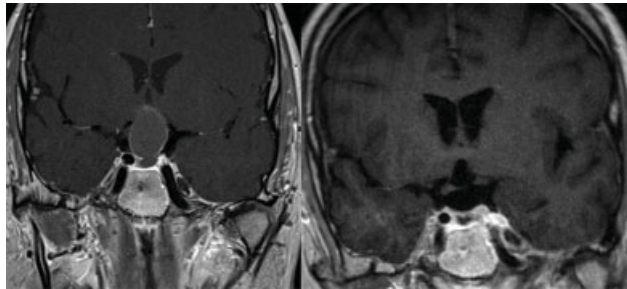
Preop and postop coronal MRI imaging of a craniopharyngioma resected using the endoscopic endonasal trans-sphenoidal approach.
